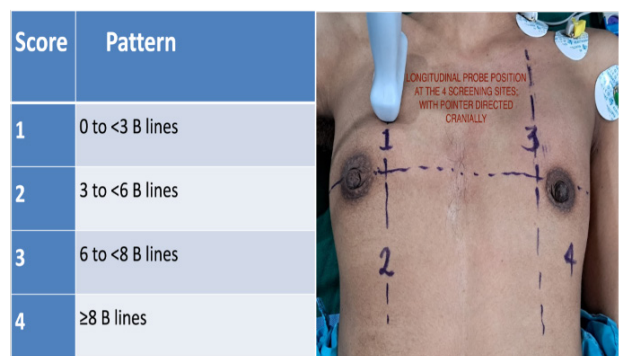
Position of the ultrasound probe and B-line score calculation in the 4-sector ultrasound protocol
